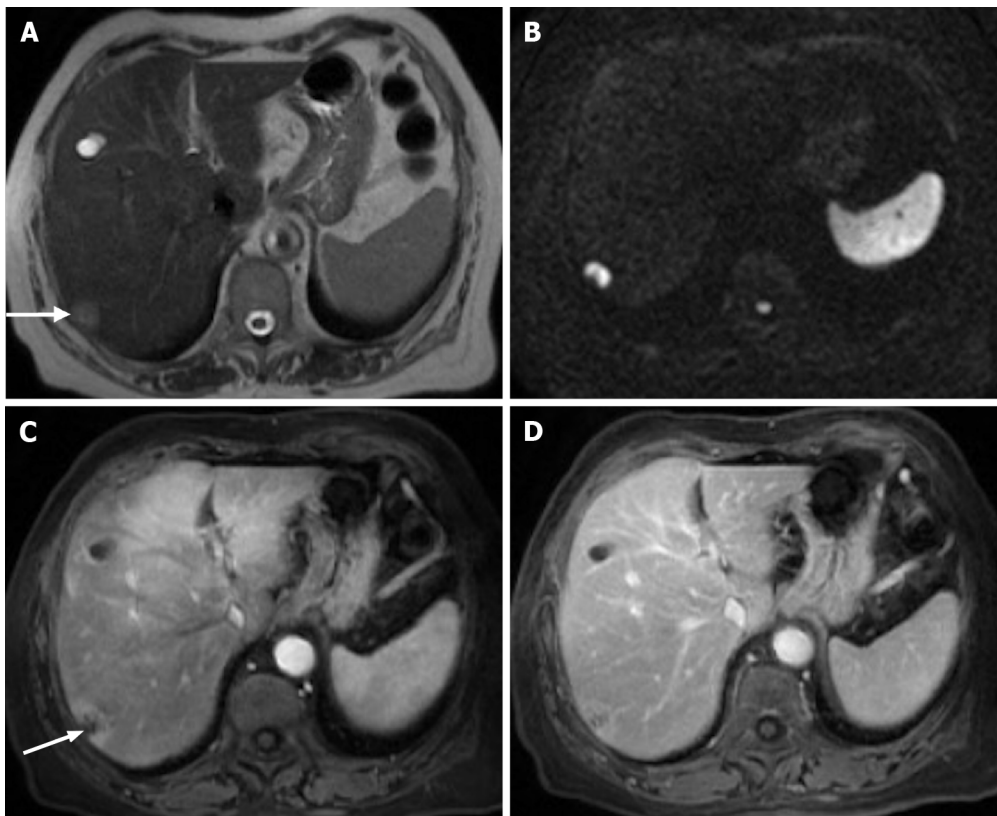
Pancreatic cancer liver metastasis is seen in the subcapsular region of segment VII. A: Axial T2- weighted imaging (WI) shows the pancreatic liver metastasis as a mildly hyperintense lesion (arrow); B: Note the very high signal intensity on high *b* value diffusion-weighted imaging; C: Axial fat saturated (FS) contrast-enhanced magnetic resonance imaging (CE-MRI) T1-WI in the arterial phase. Despite being hypovascular, it is common to find perilesional hyperenhancement in pancreatic cancer subcapsular metastases (arrow); D: Axial FS CE-MRI T1-WI interstitial phase - progressive central enhancement is appreciated in the interstitial phase.
